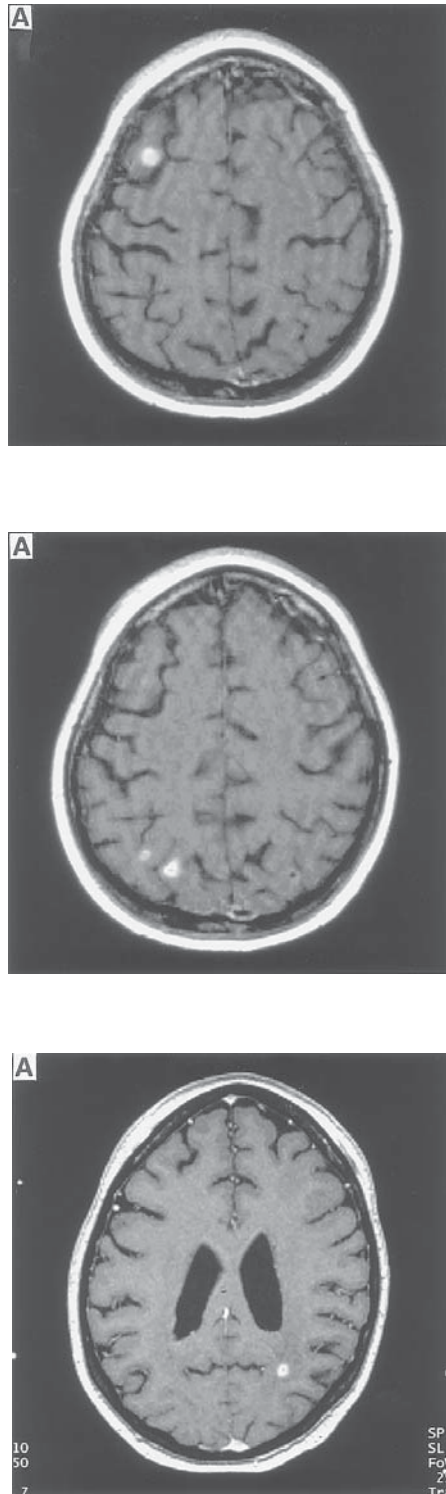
MRI scan of the brain with Gadolinium (T1 images) from a 38-yr-old woman with multiple brain metastases from RCC.
